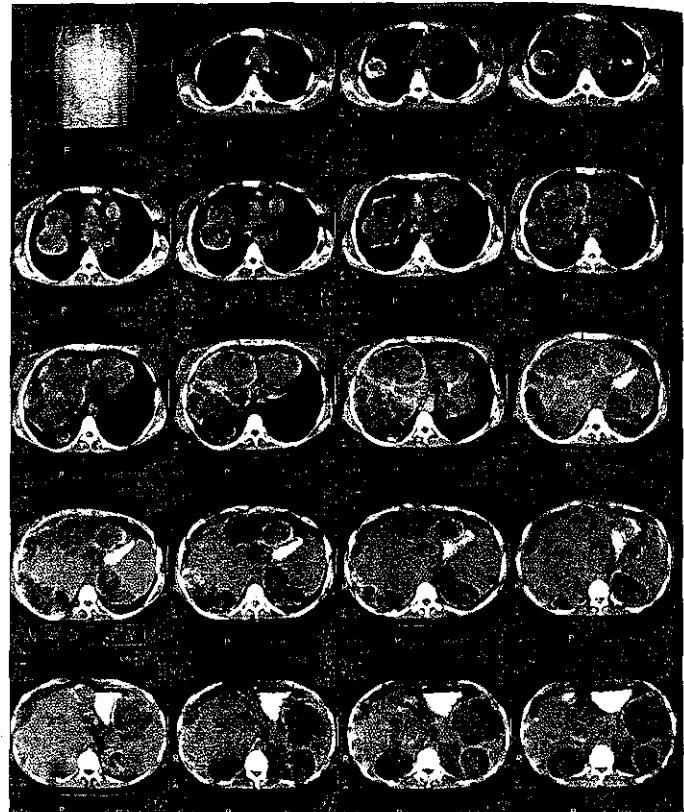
A 25-year-old woman presented with shortness of breath. CT scan showed widespread hydatid disease.
